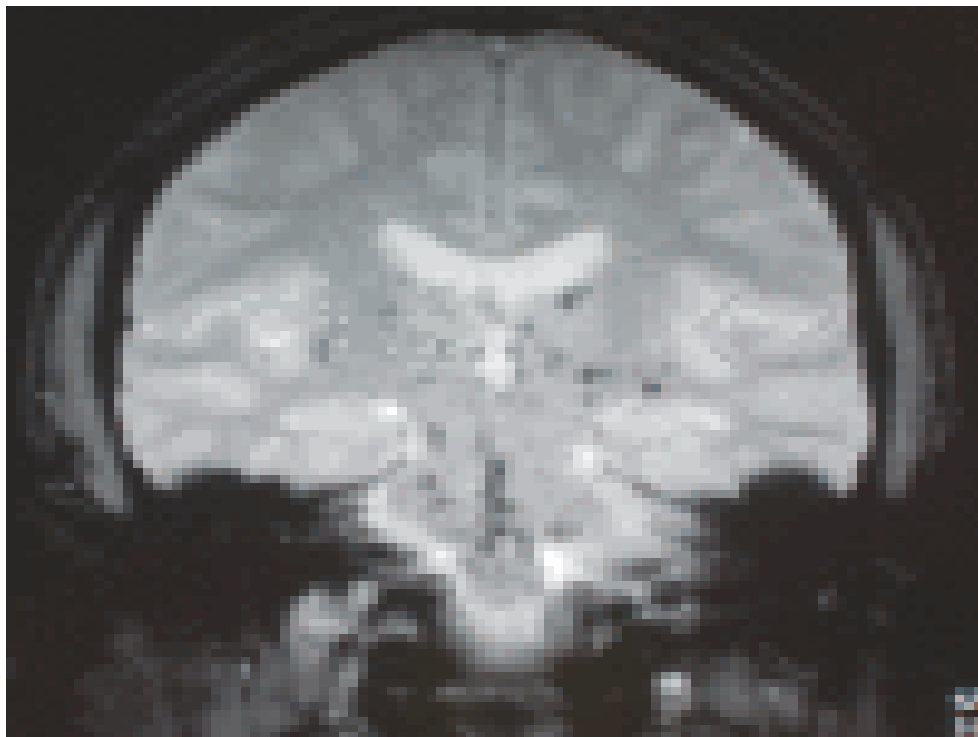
MRI Brain. There are multiple areas of low signal intensity in the pons, medulla oblongata, basal ganglia and also in the cerebral hemispheres (MRI Brain T1).
